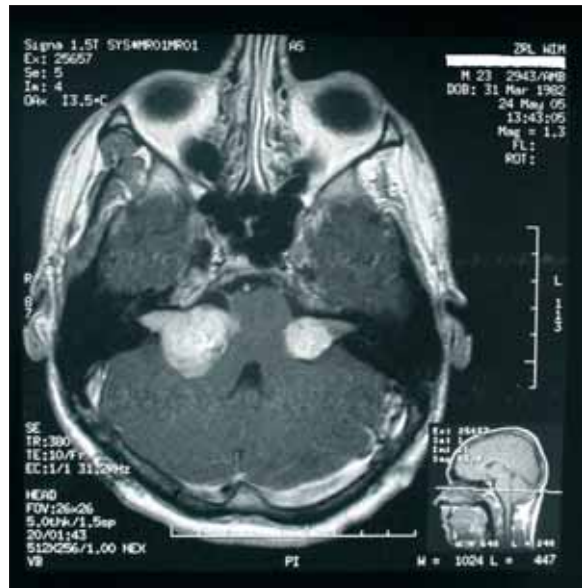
Magnetic resonance image before tumor removal.
